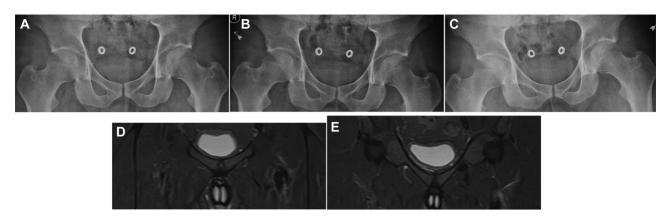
Postoperative 96-month follow-up images of a 23-year-old male patient with osteitis pubis. (A) Standing AP and (B,C) flamingo radiographs demonstrate no pubic instability. (D,E) Coronal and axial MRI scans demonstrate no evident degeneration of the pubic symphysis. AP, anteroposterior; MRI, magnetic resonance imaging.
